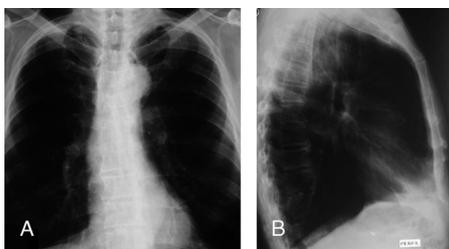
Chest radiographs: anteroposterior (A) and lateral (B) views.
